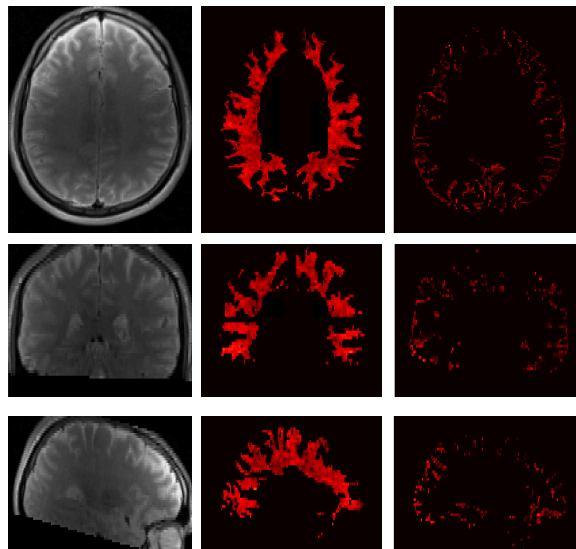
Normalized T2-weighted images, shown in all three orientations, with corresponding masked MWF maps of white (middle) and grey (right) matter.
